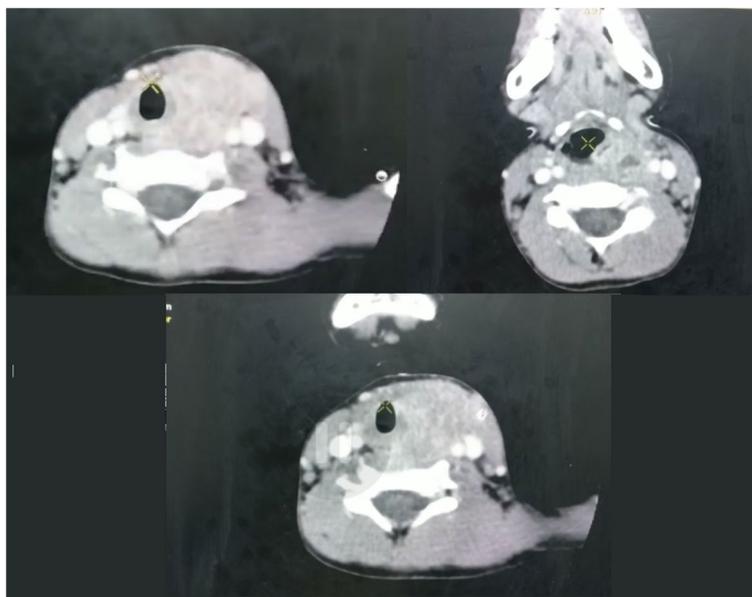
Axial CT scans showing lesion in the left side of anterior compartment of the neck, extended to the vascular space and the posterior prevertebral spaces
